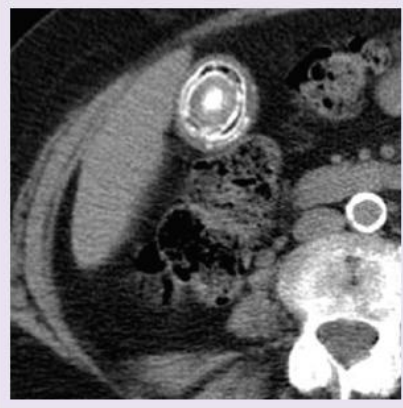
CT of the kidneys, ureters and bladder shows a large laminated gallstone in the gallbladder.
